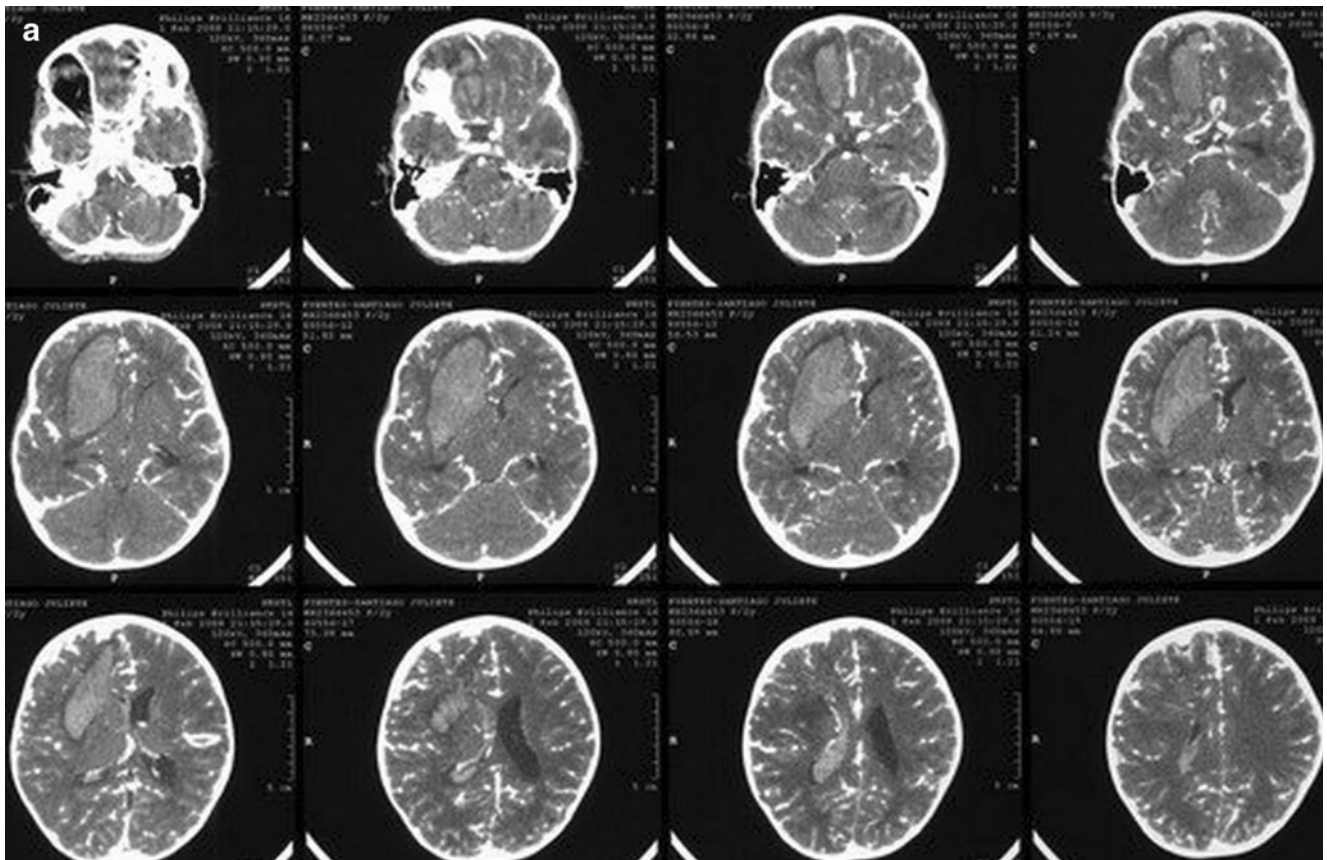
The head CT with contrast of a 3-year-old girl who presented with a left hemiparesis and lethargy demonstrated an intraparenchymal hematoma in the right frontal lobe (a). The femoral cerebral angiogram in AP and lateral projections early arterial and late arterial phase of the right and left carotid arteries injections demonstrated the areas of hypervascularity in the cortical region of the right hemisphere (b, c, d, e, f, g, h, i). The areas with early venous drainage in the area
